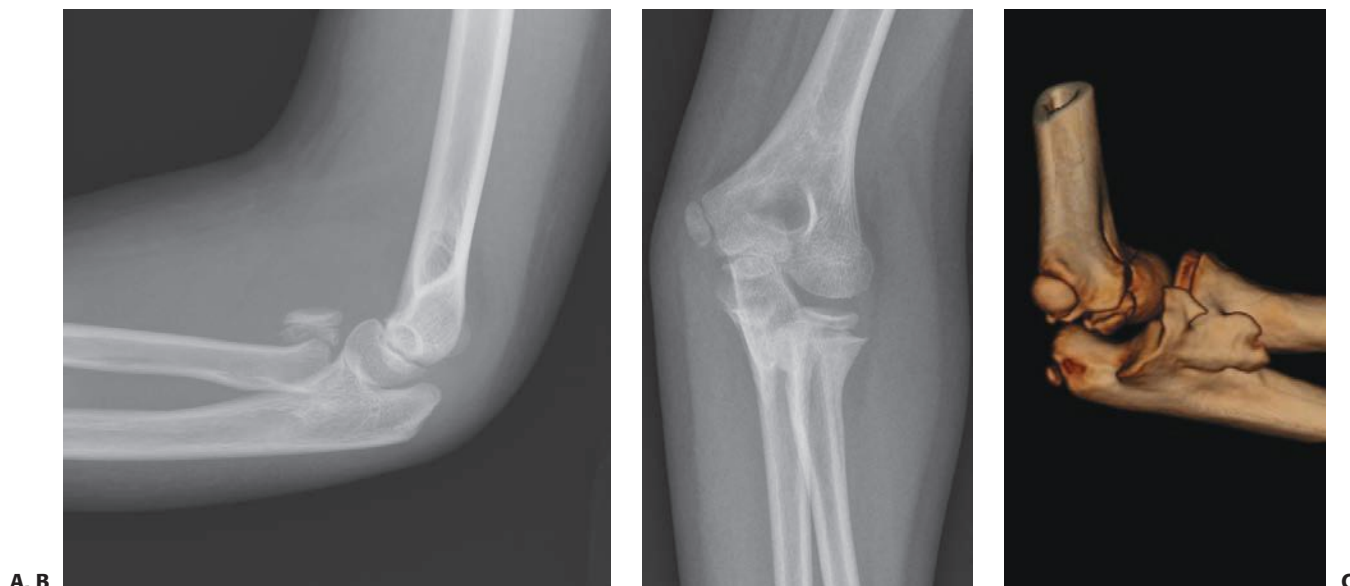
Radioulnar synostosis. An 11-year-old male fell injuring his nondominant left elbow. An elbow dislocation was reduced by emergency personnel prior to arrival at the hospital. A: Initial radiographs demonstrated a significantly displaced radial neck fracture. This was reduced using percutaneous techniques. B: Five months later radiographs and (C) a CT scan noted a complete radioulnar synostosis.
